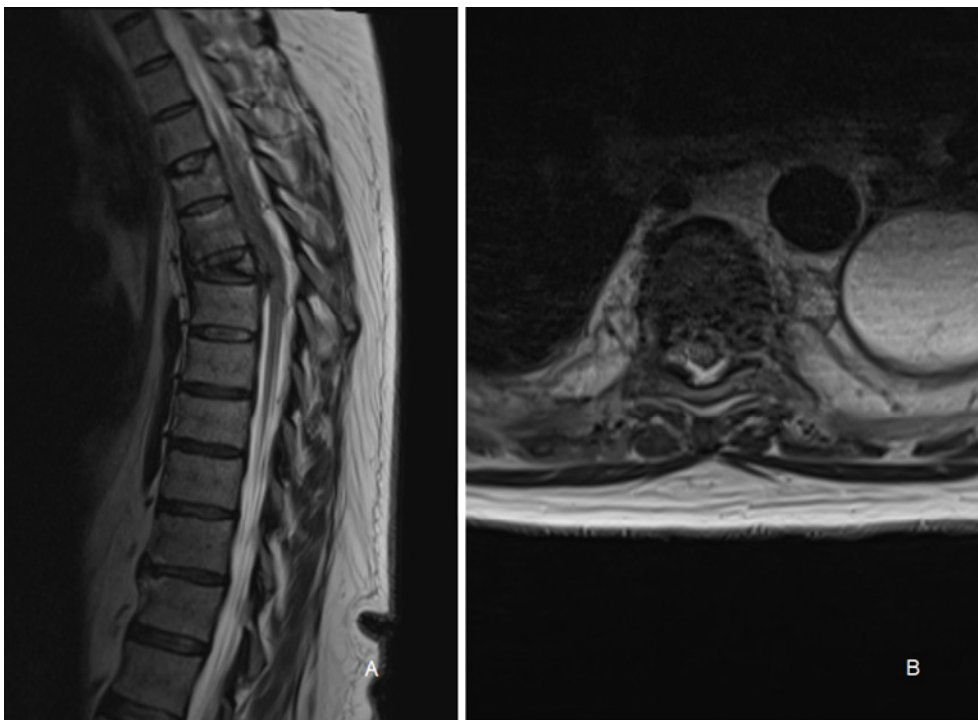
T2 sagittal and axial MRI images showing mild ventral cord compression at the level of the compression fractures with a small anterior hematoma.
